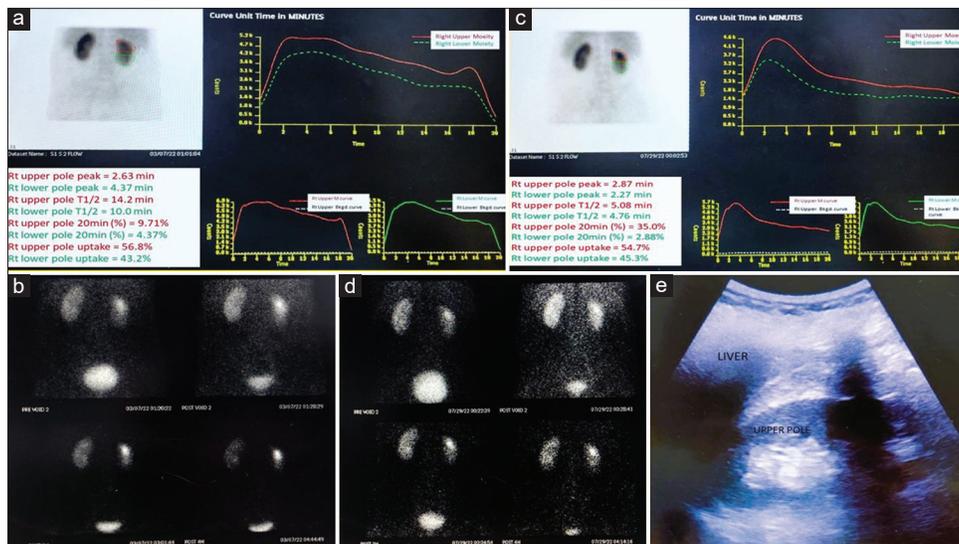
(a and b) Images of the preoperative DTPA scan: Both the upper and lower moiety curves show delayed clearance with uprising towards the end of the curve (a) and persistent tracer activity at the end of the 4 h (b). The curves are not very representative due to significant overlap in the region of interest chosen for DTPA, as the kidney was mal-rotated. (c and d) Images of the postoperative DTPA scan - Both the upper and lower moiety curves show a typical type I curve without any plateau or uprising at the end (c) and the significantly reduced tracer activity at the end of 4 h (d). Note the significant reduction in T1/2 in the postoperative curve. (e) - post operative ultrasonography image showing resolution of upper moiety hydronephrosis. DTPA: Diethylenetriaminepentaacetic acid
